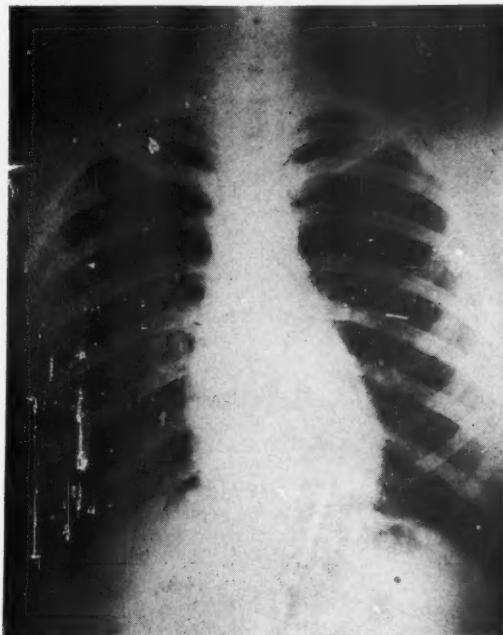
Roentgenogram of chest showing pulmonary metastases secondary to carcinoma of thyroid gland. Date of x-ray film—Feb. 18, 1936. Patient now living and well (Case 1).
